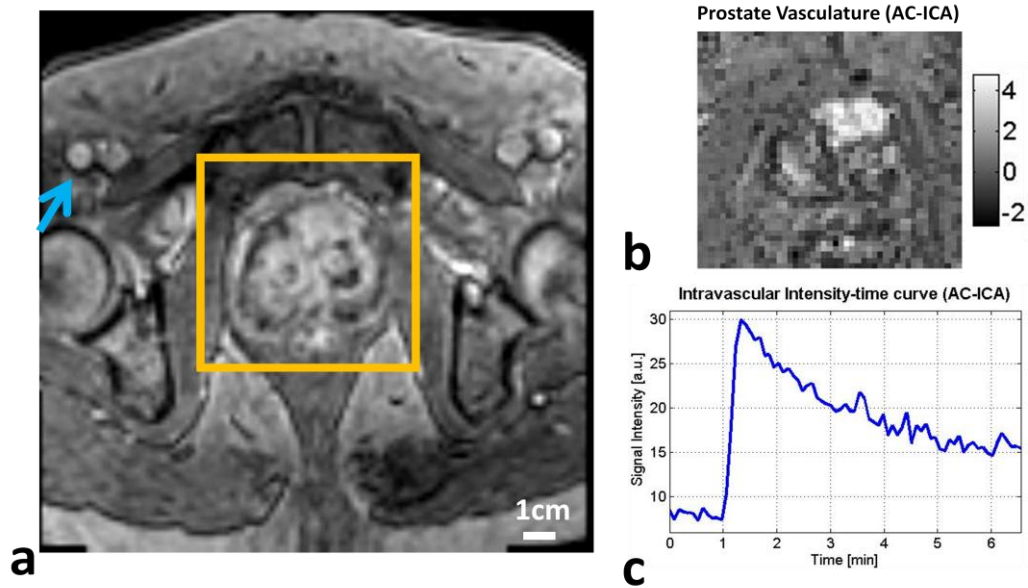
a) The full DCE-MRI field of view for a sample dataset. The independent component corresponding to the prostate vasculature separated by the AC-ICA algorithm in b) spatial domain (color-bar shows the average signal intensity of the separated IC spatially which has an arbitrary unit due to scaling ambiguity of ICA), and c) temporal domain.
